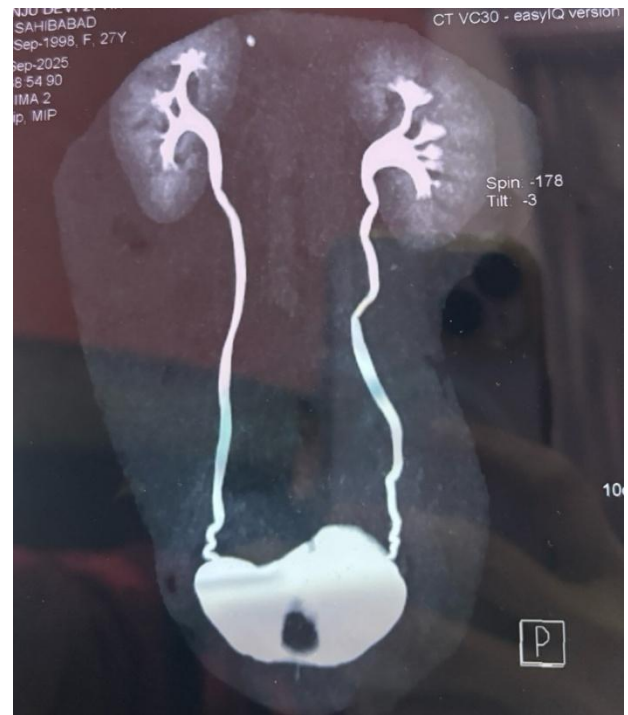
Coronal CT urography demonstrating contrast opacification of bilateral pelviccalyceal systems and ureters with filling of the urinary bladder with contrast leakage into the vaginal cavity.
